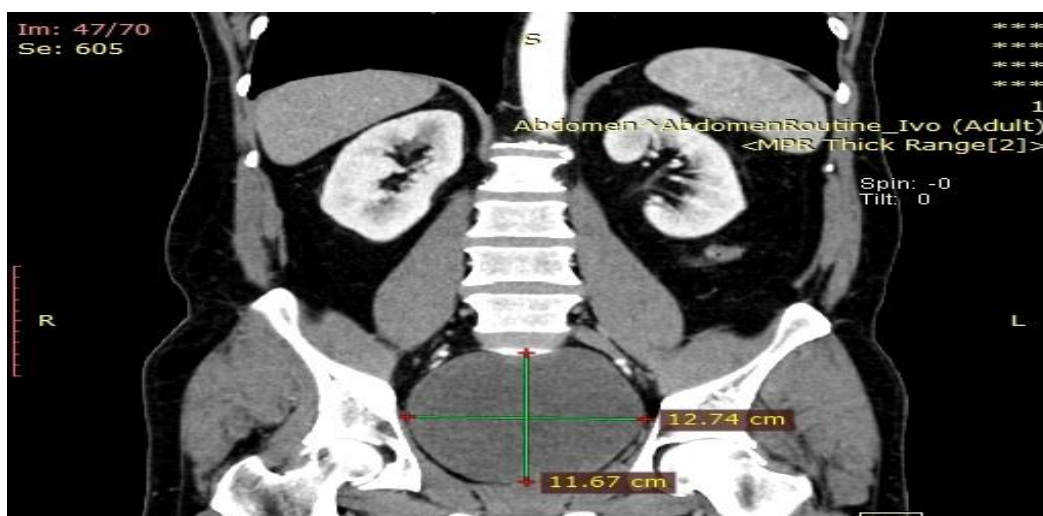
Coronal image of the tumor on CT
